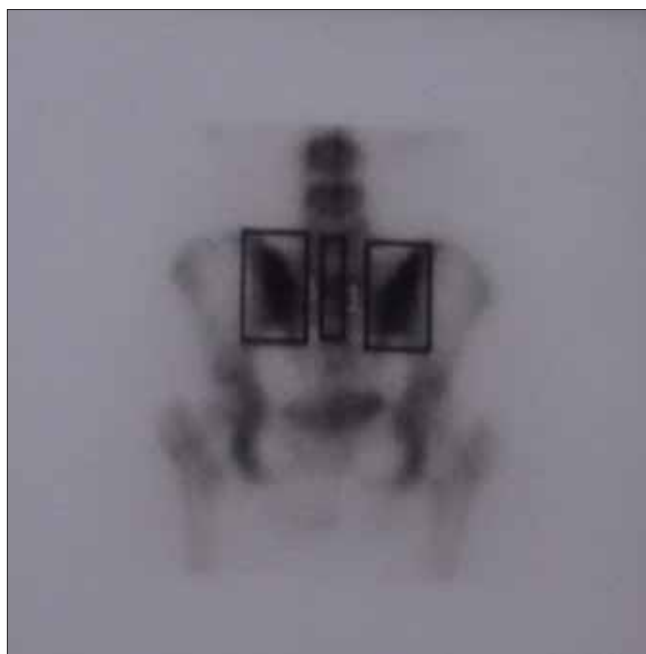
The late phase of the scintigraphy shows bilateral sacroiliitis.
